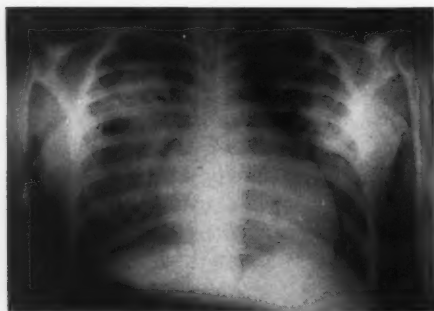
X-ray film of the chest during pulmonary edema.
